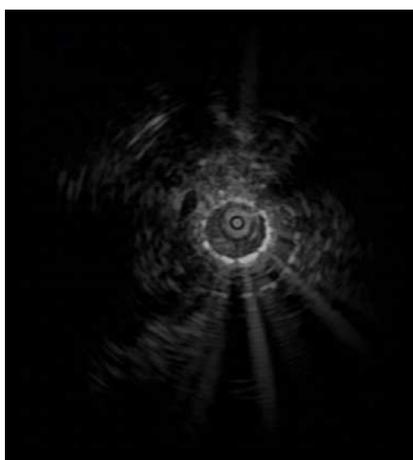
Intraductal ultrasound imaging. Homogeneous hyperechoic lesions with smooth margins of benign bile duct stricture were visualized.
